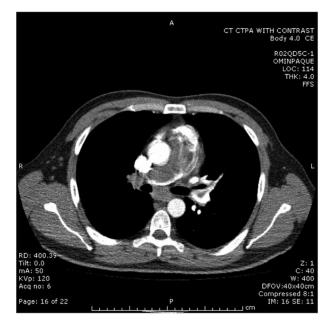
Initial chest CT scan at the level of the fifth thoracic vertebra.
